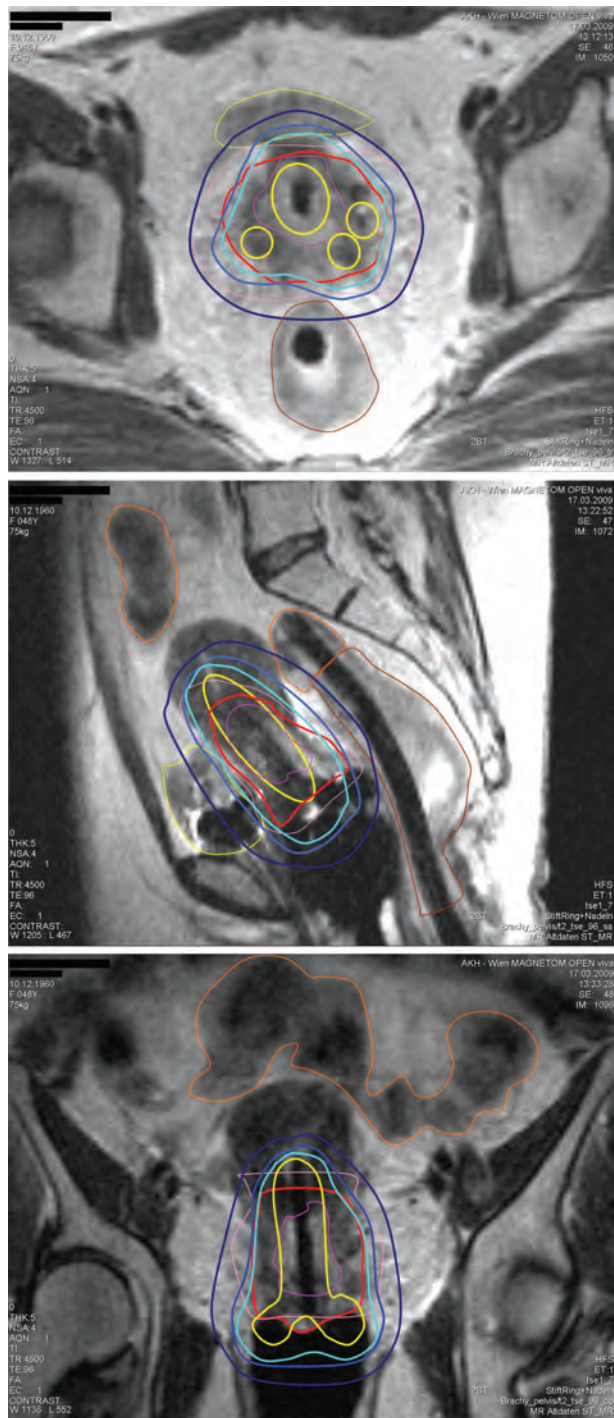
Delineation and dose distribution at second brachytherapy application on MRI with applicators in place. CTV_{HR}, thick red; CTV_{IR}, thin pink; GTV_{res}, thin magenta; bladder, thin yellow; rectum, thin brown; bowel, thin orange; EQD2₁₀ isodoselines: dark blue is 60 Gy, blue is 75 Gy, cyan is 85 Gy, and yellow is 156 Gy. These doses correspond to 3.5, 5.8, 7, and 14 Gy per fraction.
